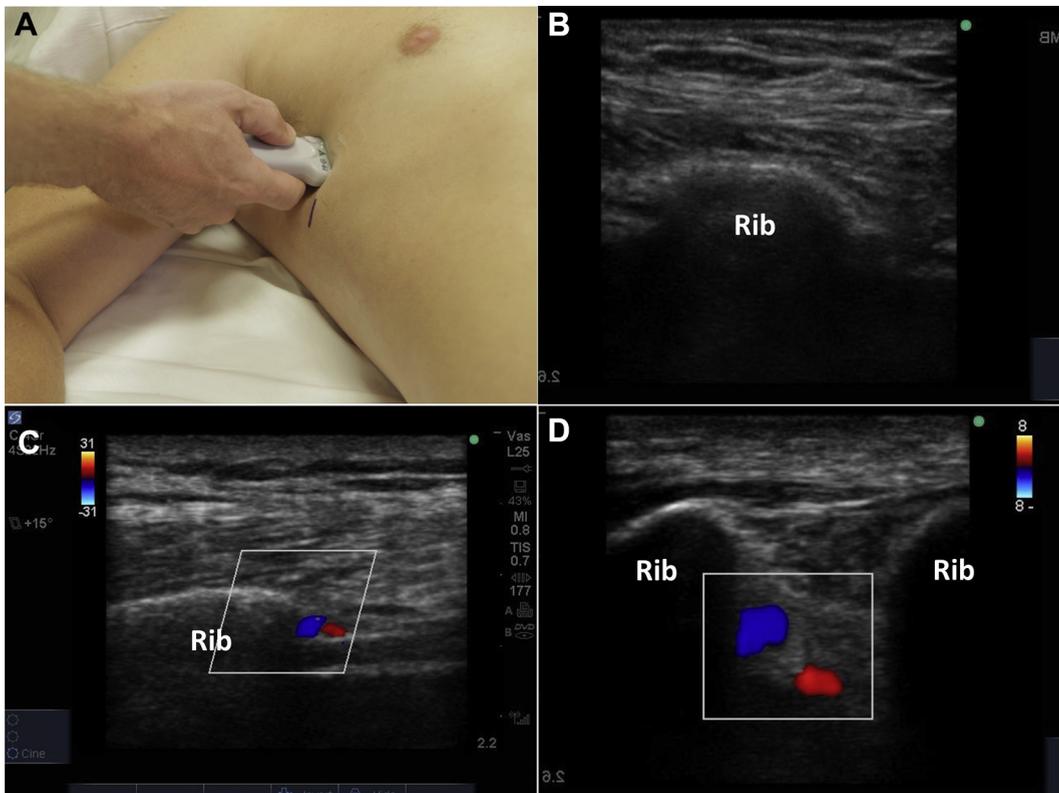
Locate the intercostal artery. A, Correct transducer position required to locate the intercostal artery (IA). In this example the transducer indicator is pointing to the patient’s feet. B, The initial view with the rib centered on the screen. Note that with the transducer in this orientation, the patient’s head is to the left of the screen. C, Finding the IA with color Doppler; here the artery is in a safe position, tucked right to the underside of the rib. D, An IA in a more dangerous position, away from the rib notch and into the middle of the intercostal space.
